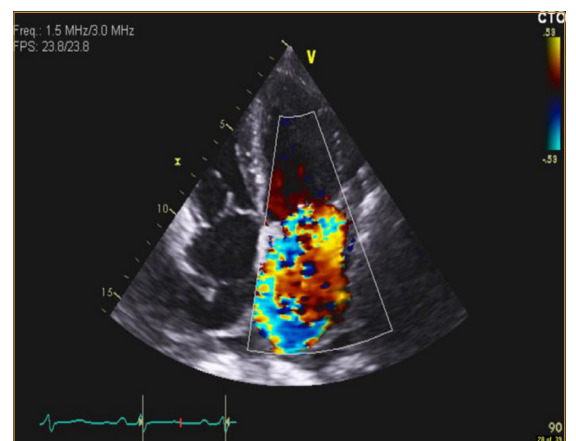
Echocardiogram four chambers view with colour flow Doppler showing a jet of mitral regurgitation reaching the upper right pulmonary vein
